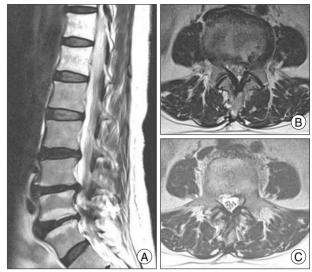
Lumbar spine MRI. A: Sagittal T2WI of the second round of MRI shows almost complete regression of the hemiated nucleus pulposus at the L4/5 level. B and C: Axial T2WI of the second round MRI shows almost complete regression of the hemiated nucleus pulposus and the remaining lateral stenosis at the L4/5 level without nerve root compression.
